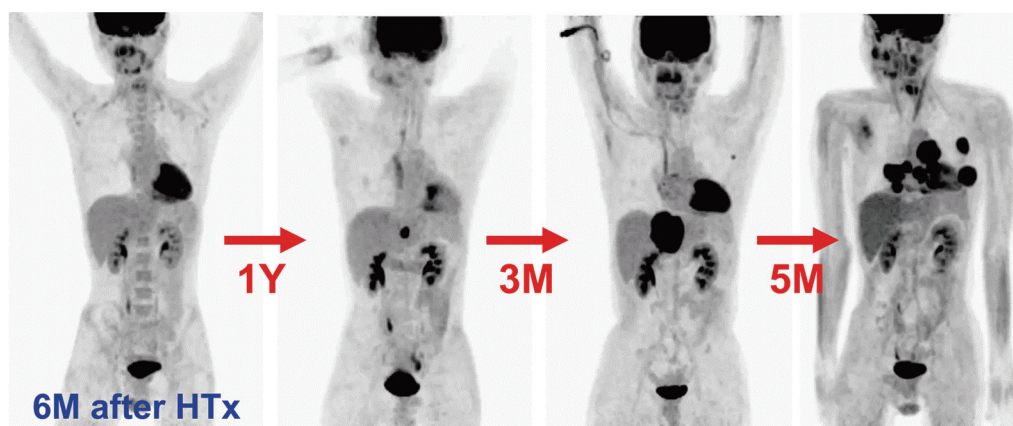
Serial findings of ¹⁸F-FDG PET imaging in patients with typical PTLD
